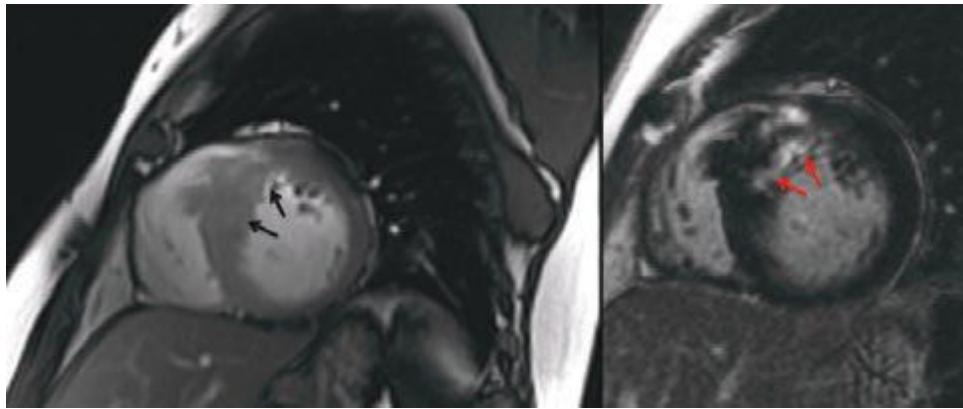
16 Magnetic resonance image with contrast enhancement in a patient with hypertrophic cardiomyopathy. Note the marked thickened anteroseptal wall (black arrows, left panel) consistent with asymmetric septal hypertrophy. After contrast is injected, this region demonstrated heterogeneous foci of contrast enhancement (right panel, red arrows) consistent with myocardial fibrosis due to myofibril disarray in this condition. This typical enhancement pattern of hypertrophic cardiomyopathy is found in the areas of maximum wall thickness, typically at the anteroseptum as in this case. (See Video 271e-16.)
